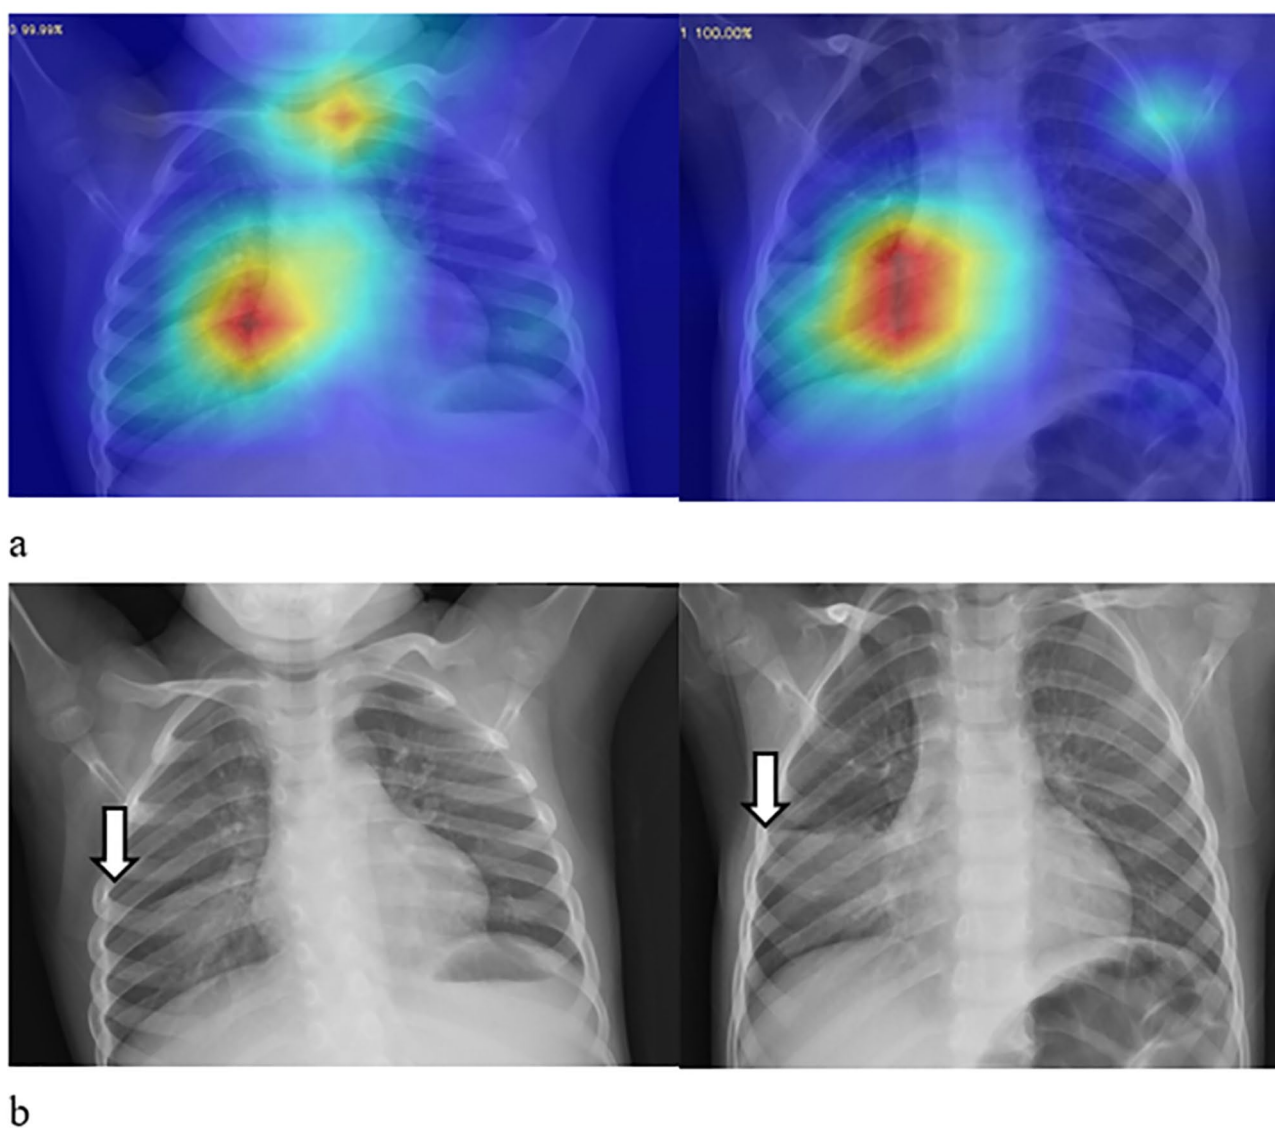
The recognition of pathology areas by the model and human experts for sample pediatric chest radiographs in mycoplasma pneumonia. Respectively, (a) the original images with superimposed class activation maps to highlight the areas considered to be important in identifying the etiology by the model (b) the most clinically significant regions of pathology recognized by radiology experts (labeled by arrows). In (a), red regions correspond to high evidence for the pathogeny
